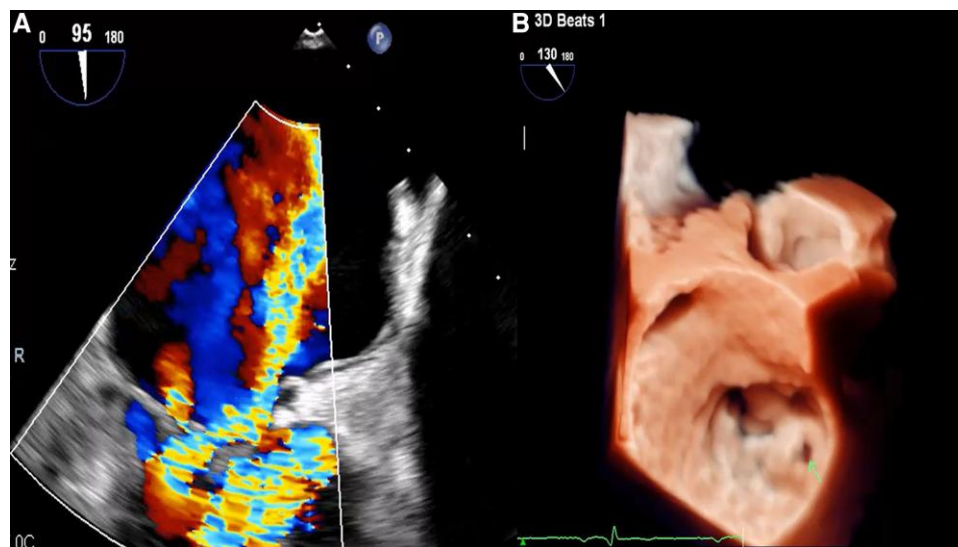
(A and B) Transoesophageal echocardiography showing mitral valve P2/P3 prolapse with suspected perforation (green arrow) of the posterior leaflet giving mitral regurgitation.
